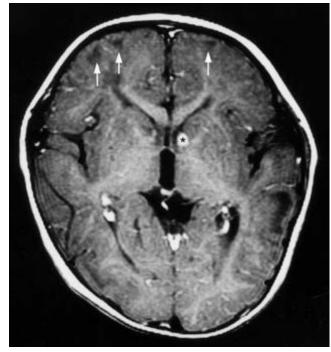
Rhabdomyoma with tuberous sclerosis in an 1-year-old infant. A. Subcostal echocardiogram shows rhabdomyomas (asterisk) in the left ventricle (LV). B. Contrast-enhanced T1-weighted MR image of the brain shows a subependymal tuber (asterisk) along the frontal horn of the left lateral ventricle and multiple subcortical tubers (arrows). Ao, aorta; LV, left ventricle; RA, right atrium; RV, right ventricle.
